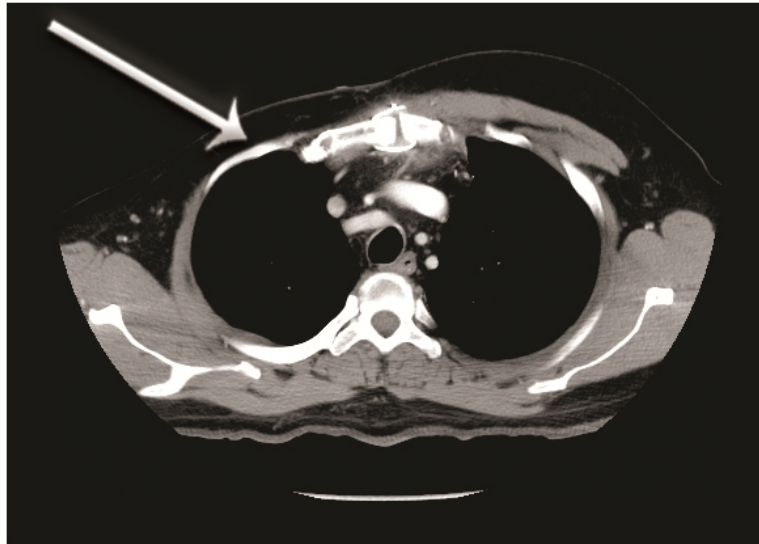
CT scan of Poland's syndrome deformities. The arrow shows the area where the pectoralis muscle is absent (<http://radiopaedia.org/articles/poland-syndrome>).
